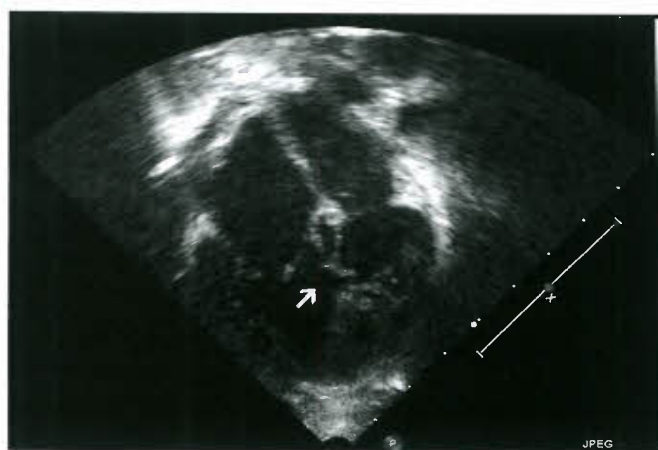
Apical four-chamber view in congenitally corrected transposition of the great arteries demonstrating herniation of the tricuspid valve septal leaflet (TV) into the ventricular septal defect. Arrow indicates septal leaflet of TV.
